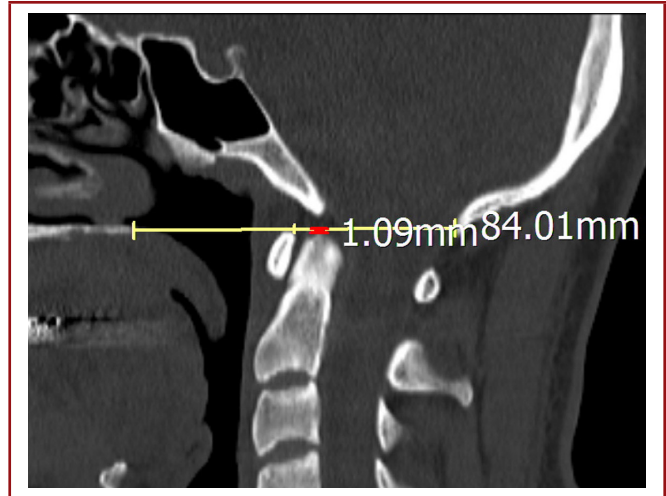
The distance from the tip of the odontoid to the Chamberlain line was determined as follows. A line was drawn from the posterior hard palate to the tip of the opisthion (the Chamberlain line) on a sagittal CT image.
